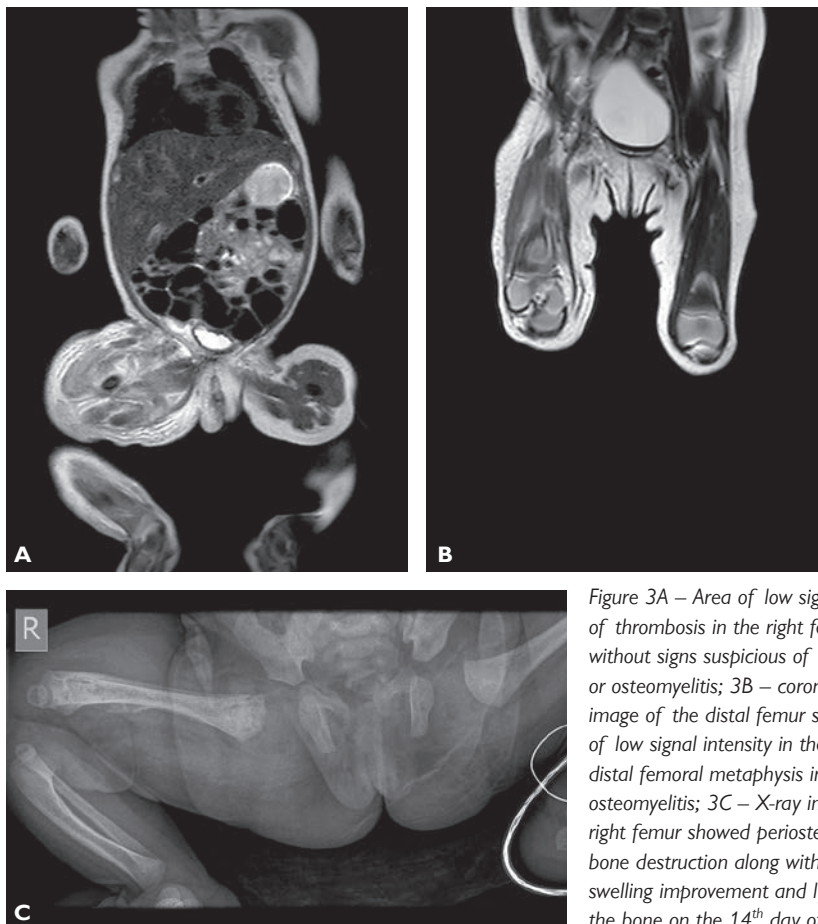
Area of low signal in the site of thrombosis in the right femoral lumen, without signs suspicious of bone malignancy or osteomyelitis; 3B – coronal T1-weighted image of the distal femur shows an area of low signal intensity in the right medial distal femoral metaphysis indicative of osteomyelitis; 3C – X-ray imaging of the right femur showed periosteal reaction and bone destruction along with deep soft tissue swelling improvement and lytic changes in the bone on the 14th day of admission.
